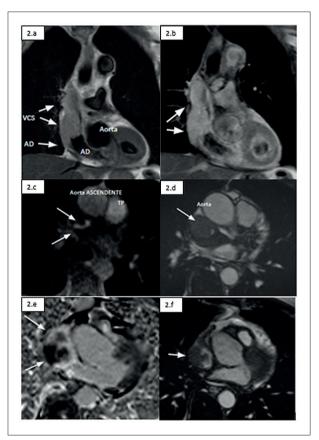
Magnetic resonance imaging of the heart showing a mass inside the right atrium (RA), occupying virtually the entire atrial appendage and infiltrating the proximal portion of the superior vena cava (SVC): 2.a) Straight axial section of the chest at the level of the SVC: mass (white arrows) with heterogeneous signal in the cine steady-state free precession (cine-SSFP) sequence. 2.b) Straight axial section of the thorax at the level of the right atrial appendage: mass (white arrows) with heterogeneous signal in the cine-SSFP sequence. 2.c) Coronal section of the chest sectioning the RA and SVC: infiltrative mass (white arrows) with hyperintensity on T1 in the Double-Inversion Recovery (DIR) sequence. 2.d) Coronal section of the chest sectioning the RA and SVC: infiltrative mass (white arrow) with hypersignal on T2 in the DIR sequence 2.e) Straight axial section of the chest at the level of the SVC at its mouth in the RA: infiltrative mass (white arrows) with heterogeneous signal in the first-pass dynamic perfusion sequence. 2.f) Straight axial section of the chest at the level of the right atrial appendage: mass (white arrow) with heterogeneous signal in the delayed enhancement sequence.
